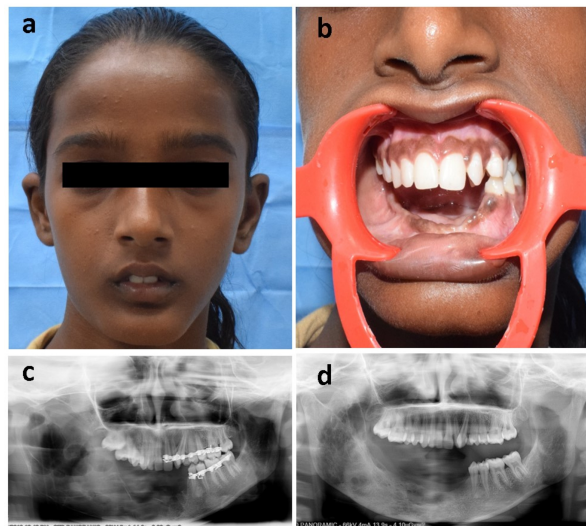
One year follow up. a. Grossly symmetrical face; b. satisfactory surgical site healing; c. Immediate postoperative orthopantomogram; d. One-year postoperative orthopantomogram reveals significant increase in radiopacity suggestive of adequate bone formation in the surgical site.
